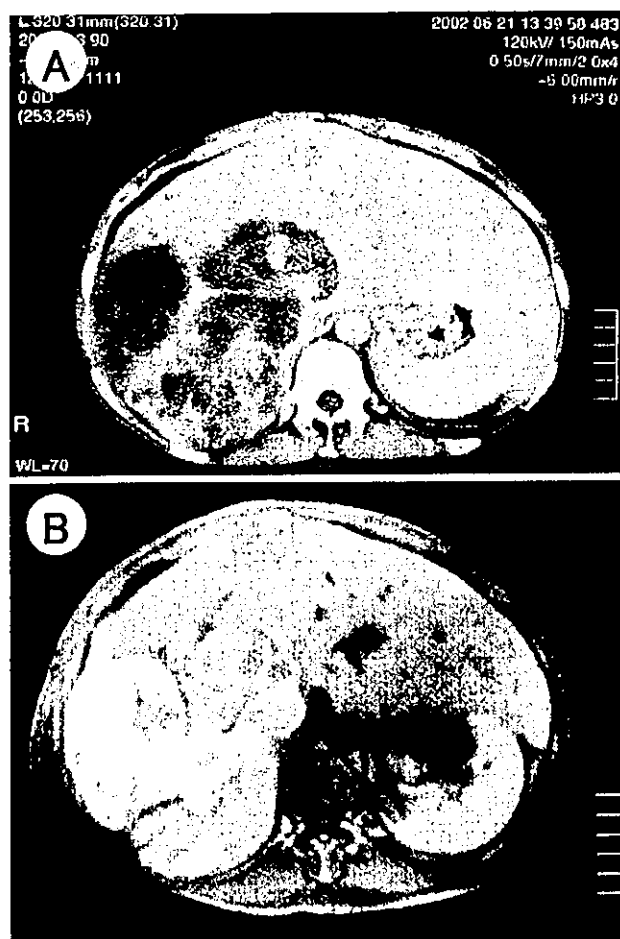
A Abdominal computed tomography (CT) demonstrated that the liver was markedly swollen, and that a massive tumor had disseminated and infiltrated pervasively through almost the entire liver. B The hepatic mass showed high intensity on a T1-weighted magnetic resonance image
